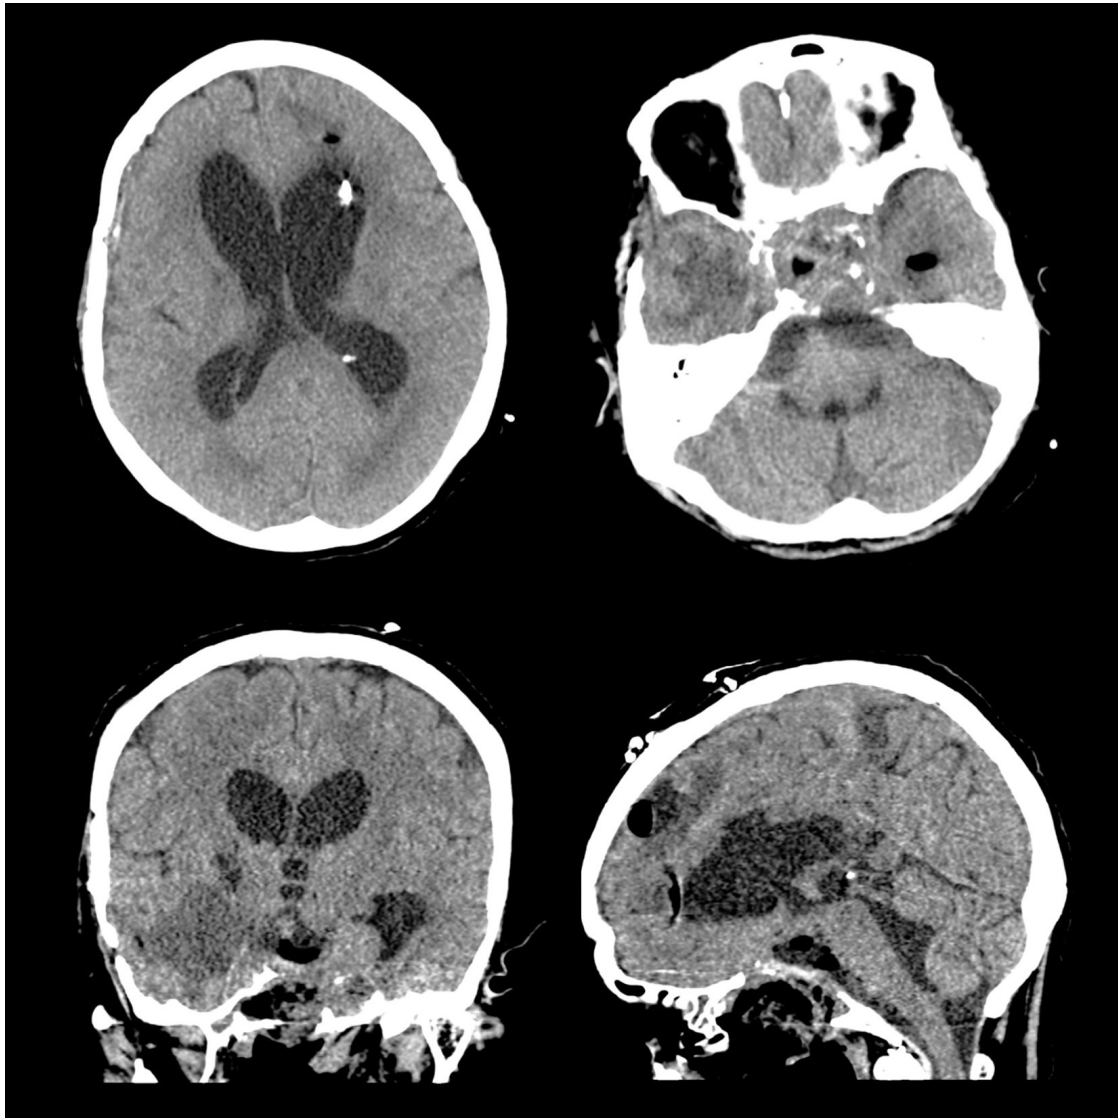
Brain computed tomography image 10 days after flap repositioning. Improvement of pneumocephalus and hydrocephalus is observed.
